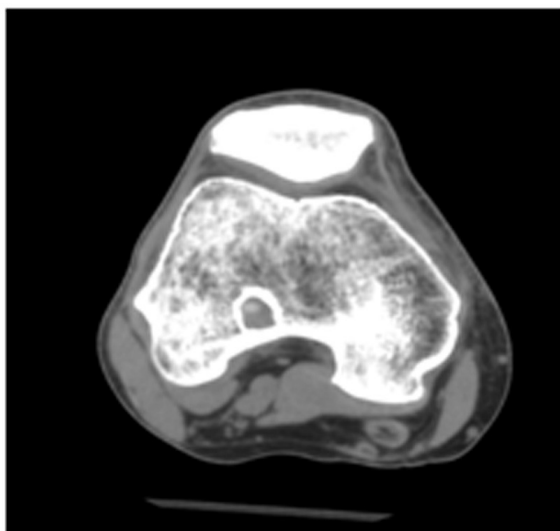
CT coronal section; left distal femur at 2 years after ACL reconstruction with LARS: neoligament surrounded by sclerotic halo and phenomenon of “spongiosizzazione” with bone density reduction.
